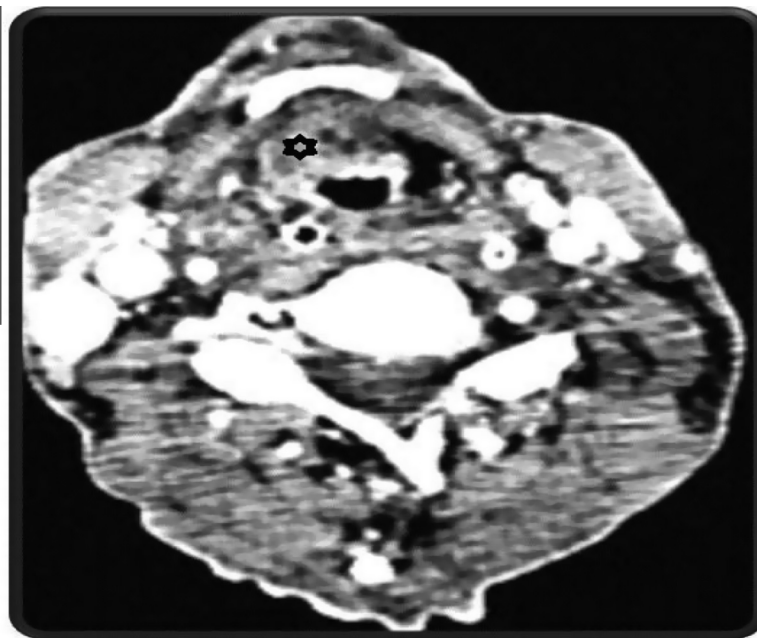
Contrasted CT scan at the level of hyoid bone showing soft tissue density at the preepiglottic space extending to the right paraglottic space.
